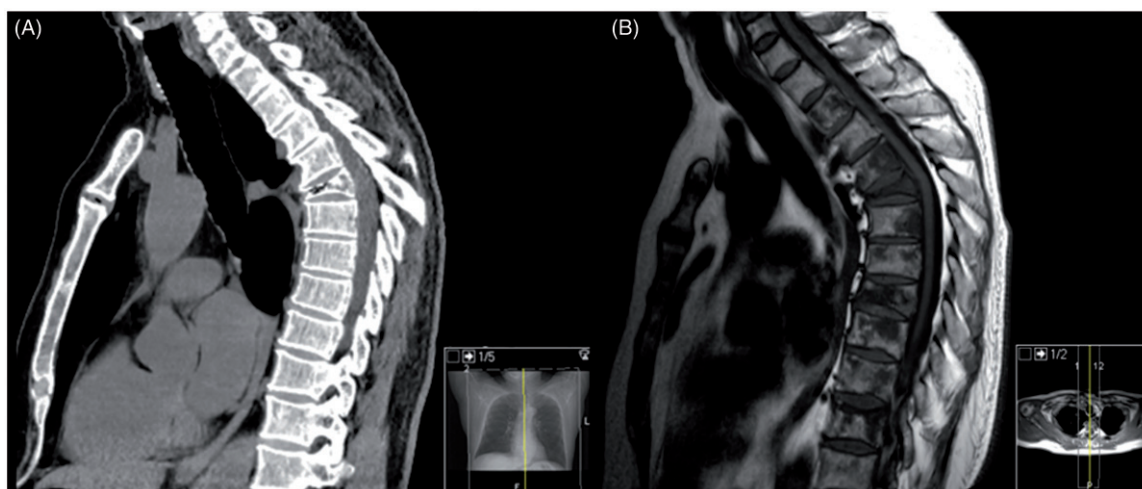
Comparison of imaging modalities. Computed tomography (CT) shows the compression fracture of Th5 but fails to visualize extensive primary bone lymphoma lesions in the thoracic spine detectable on MRI. (A) CT sagittal reconstruction without iv contrast. (B) T1-weighted sagittal MRI. Patient information and technical details were removed and images were cropped and scaled to similar frames but not changed otherwise.
